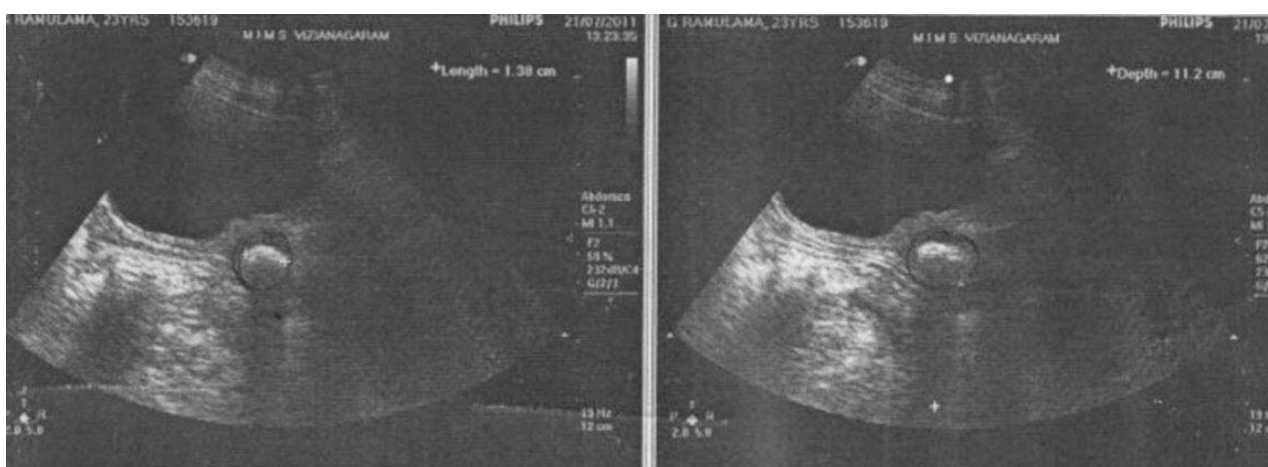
Ultrasonogram showing echogenic shadow with posterior shadowing in the region of urethra
